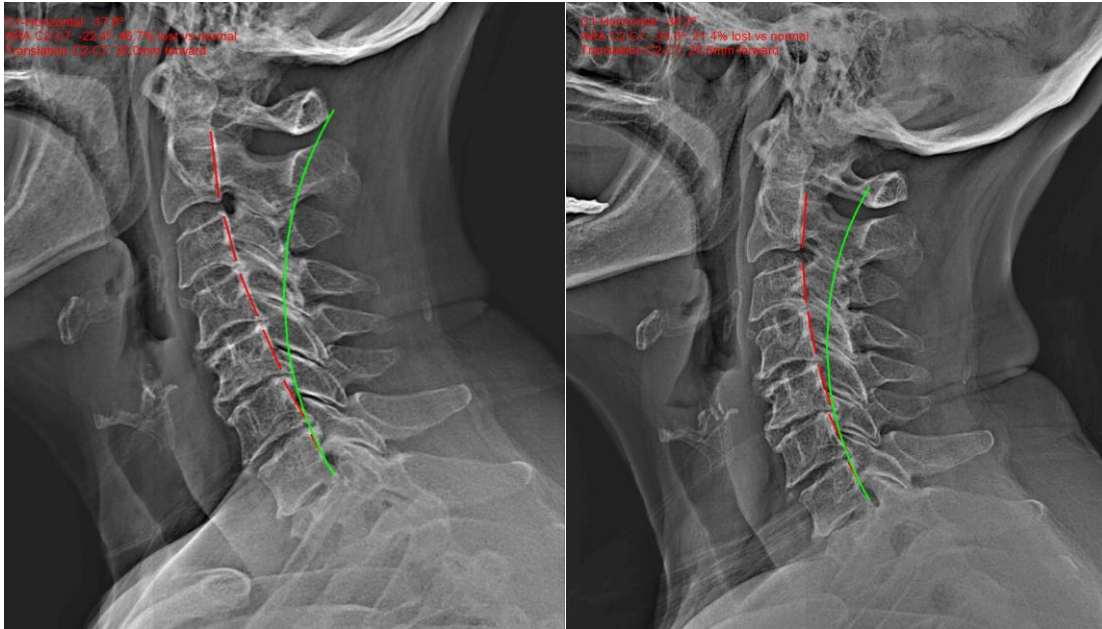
Lateral cervical radiograph views in standing neutral position. Left: Initial view (6/6/2012) demonstrating 35mm forward head posture (FHP), absolute rotation angle (ARA C2-C7) of -22° , and an atlas plane line (APL) of -18° ; Right: 10.5-week follow-up (8/23/12) showing reduction of FHP (21mm), increase in cervical lordosis (ARAC2-C7= -33°), and increased APL (-30°).
